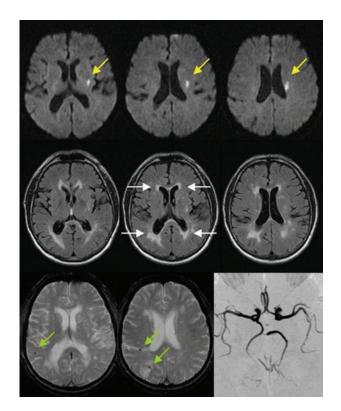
Typical MRI findings in a 78-year-old stroke patient with cerebral microangiopathy. DWI (upper row) shows a single hyperintense acute ischemic lesion in the territory of a perforating artery (arrow). The T2-weighted FLAIR technique (middle row) demonstrates quite extensive chronic white matter lesions in a pattern typical for SVE with hyperintense lesions in the para- and periventricular white matter. T2* susceptibility-weighted sequences (bottom left and middle) show several small cortical/subcortical microbleeds, while the MRA (bottom right) demonstrates irregular contrast of intracranial vessels–a finding suggestive of arteriosclerosis.
